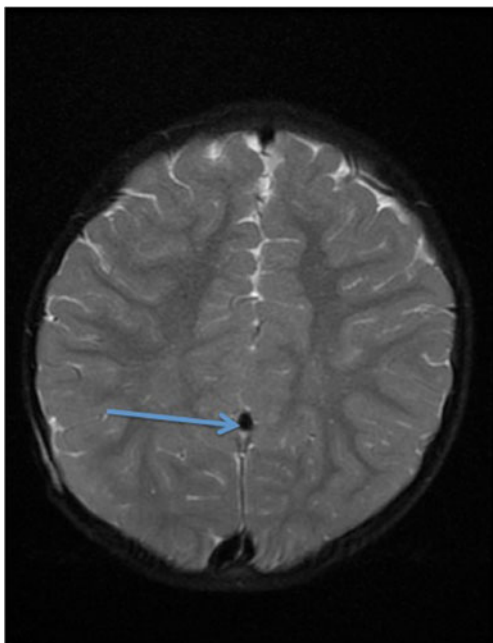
Axial MRI of the brain of the patient seen in Fig. 6. Note the persistent vein at the arrow tip
